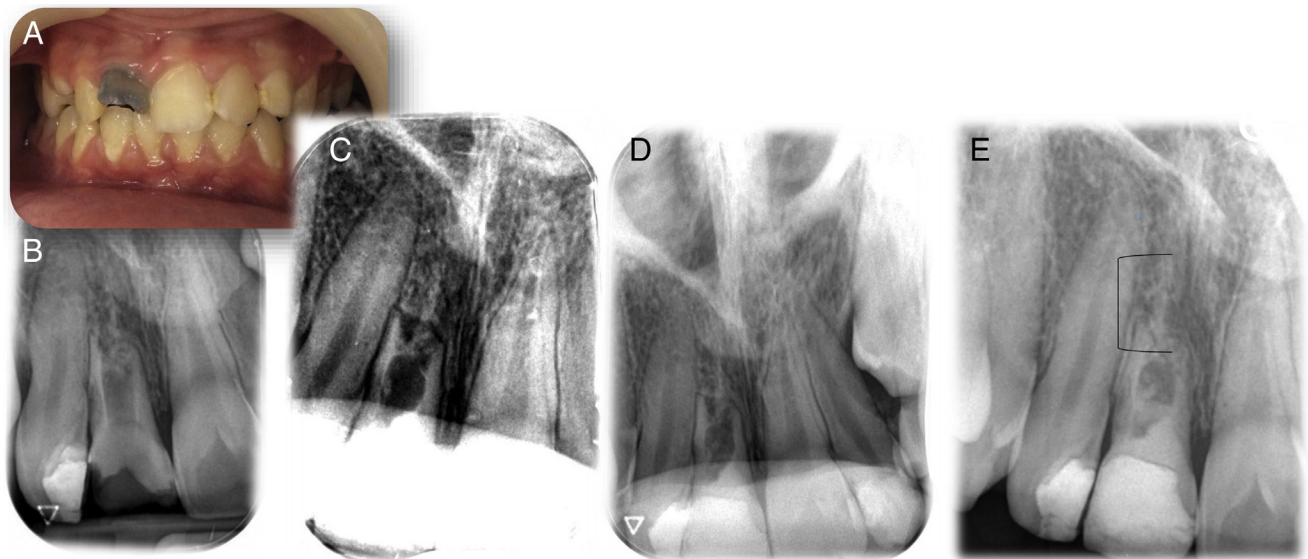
Case 2: endodontic regenerative treatment of tooth #8 after avulsion and reimplantation. (A) A clinical view of tooth #8. (B) The preoperative periapical radiograph of tooth #8. (C) The periapical radiograph taken upon finishing PRF insertion. (D) The periapical radiograph taken 6 months after the regenerative treatment. (E) The 22-month follow-up periapical radiograph showing root elongation (arched arrow).
